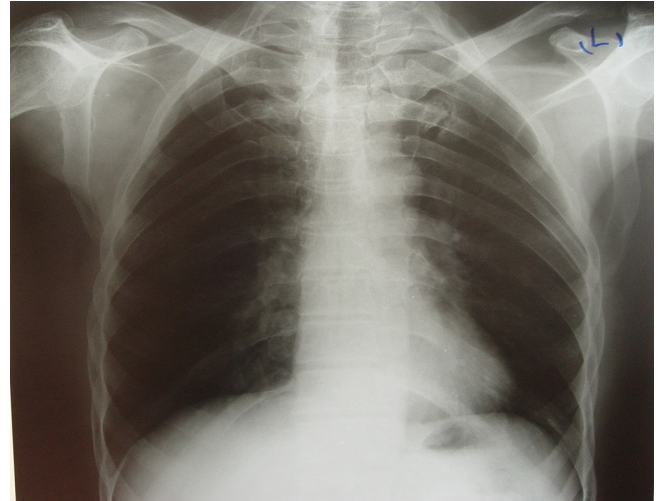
Chest X-ray PA.No lesion or pulmonary Hillary lymph Node is seen.
